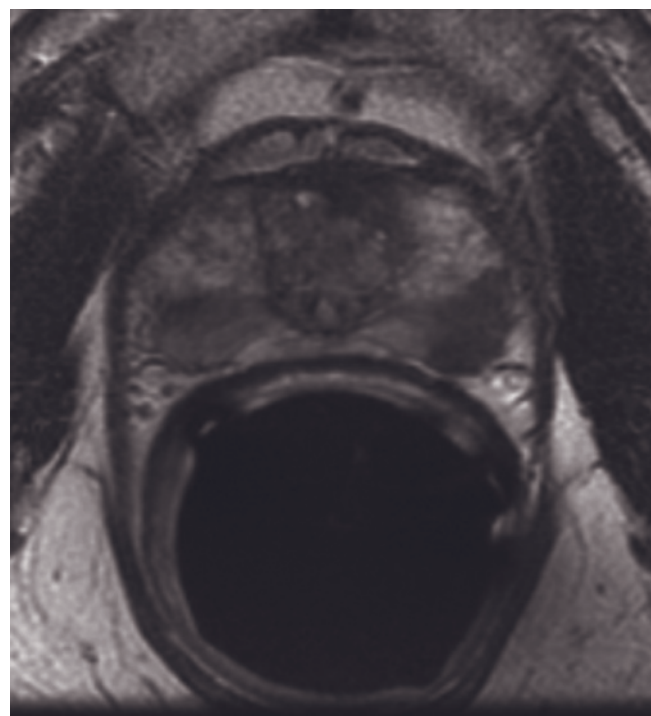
Prostate carcinoma with capsular penetration. T2-weighted ETSE endorectal image (*a*) demonstrates low-signal-intensity tumor within the peripheral zone of the prostate that extends posterolaterally (arrow, *a*), indicating capsular penetration. Transverse (*b*) and sagittal (*c*) T2-weighted ETSE images in a second patient demonstrate diffuse low signal intensity of the peripheral zone, consistent with diffuse carcinoma. Capsular penetration is observed at the 8 o'clock position (arrow, *b*). Seminal vesicle invasion is clearly shown in the sagittal projection (arrow, *c*), with involvement of the bladder base also appreciated. Prostate carcinoma with extracapsular extension, Stage T3a. Transverse high-resolution T2-weighted fast spin-echo image (*d*) demonstrates low-signal-intensity tumor within the transitional and peripheral zones of the prostate bilaterally showing extracapsular extension (arrows), invasion of anterior perirectal fascia (arrows), and obliteration of rectoprostatic angles (arrows). The tumor and its extracapsular extension show prominent enhancement on transverse arterial-phase postgadolinium fat-suppressed 3D-GE image (*e*). Time-signal intensity curve of the dynamic 3D-GE
